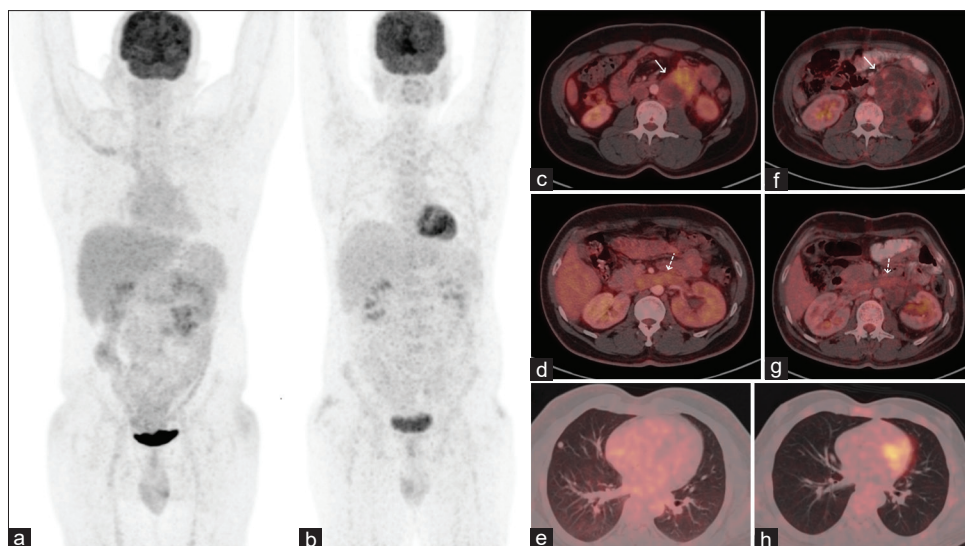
Restaging fluorodeoxyglucose positron emission tomography-computed tomography (a and b MIP) done for response assessment shows near-total resolution of fluorodeoxyglucose-avid focus in the left-sided abdomen. Transaxial images show significant interval reduction in the metabolic activity of left-sided retroperitoneal lesion (c and d; white solid arrows; SUVmax - 6.8 vs. 2.4), and tumor thrombus (e and f; white dashed arrows; SUVmax - 3.8 vs. 2.2) along with the total resolution of lung nodule (g and h)
